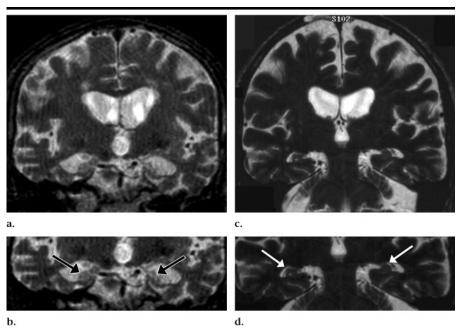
Coronal T2-weighted fast spin-echo MR images (repetition time msec/echo time msec, 2,700/80) in (a, b) a patient with AD and (c, d) an age-matched control subject. (a, b) The patient with AD has severe bilateral hippocampal atrophy (arrows). Compare this with (c, d) normal hippocampus (arrows) in the control subject. Note that b is a close-up of a, and d is a close-up of c. (Images courtesy of Daniel P. Barboriak, MD, Duke University Medical Center, Durham, NC.)
